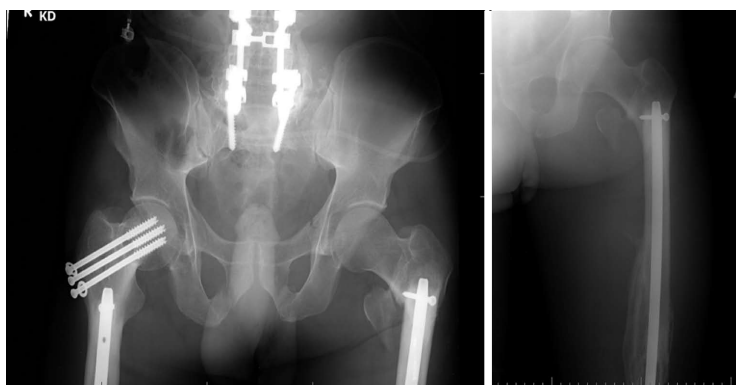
Anteroposterior and lateral radiographs of left femur showing peri-implant fracture involving the interlocking screw site in the subtrochanteric area.
